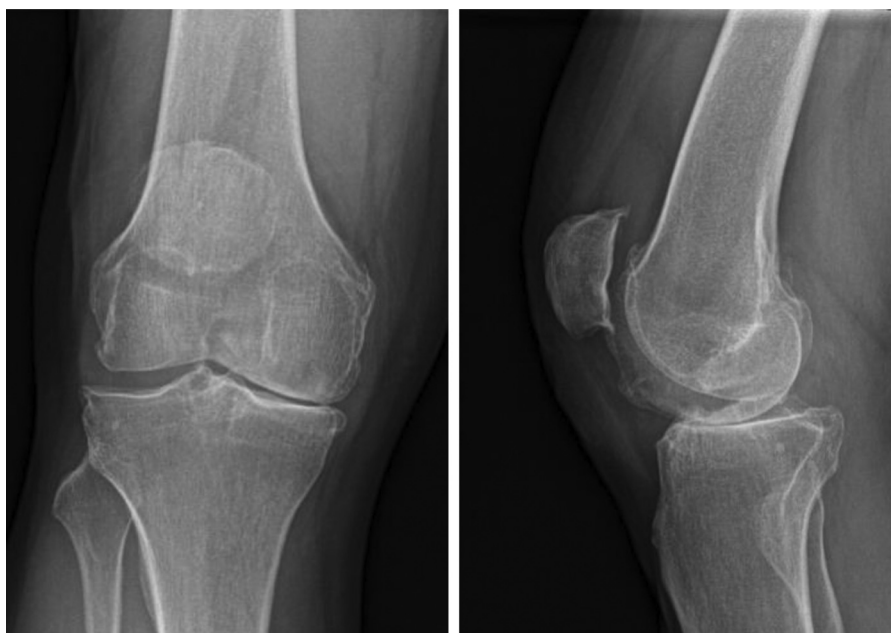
Anteroposterior (left) and lateral (right) radiograph performed 3 months before the operation.
